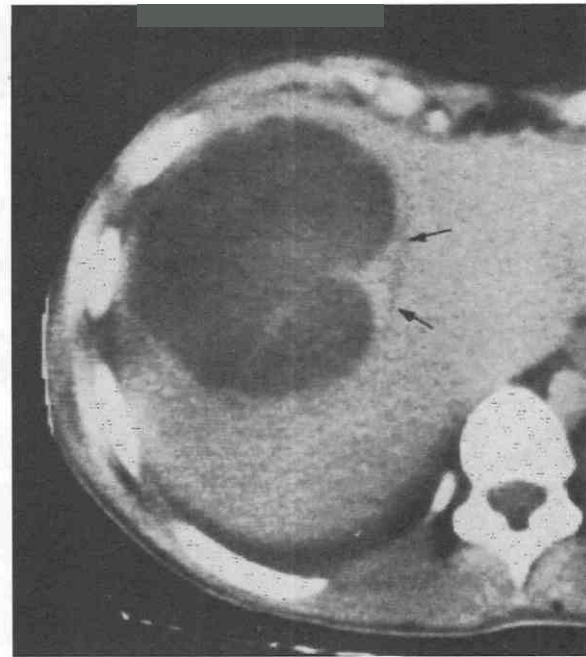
Amebic abscess. Contrast-enhanced CT scan shows that the peripheral low-attenuation rim (arrows) defines the outer limit of the inflammatory wall. An internal septum is present in the large, low-attenuation central cavity.
